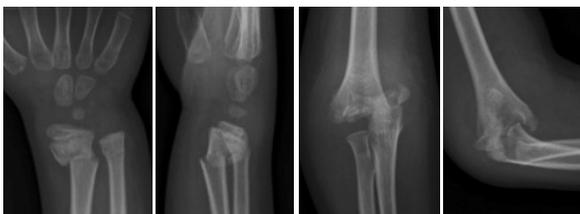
Pre-operative X-ray of right wrist and elbow
